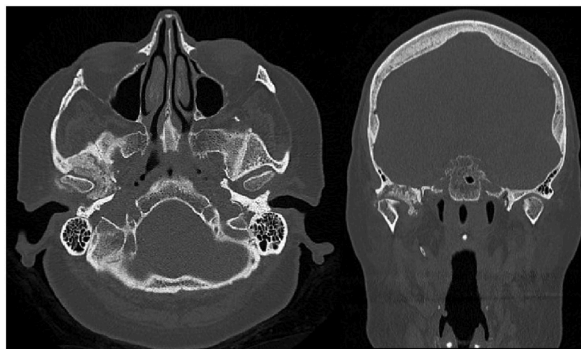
Axial and Coronal CT scan demonstrating the presence of a calcified mass centered in the right TMJ extending medially into the infratemporal fossa and mass eroding into the floor of the middle cranial fossa.
